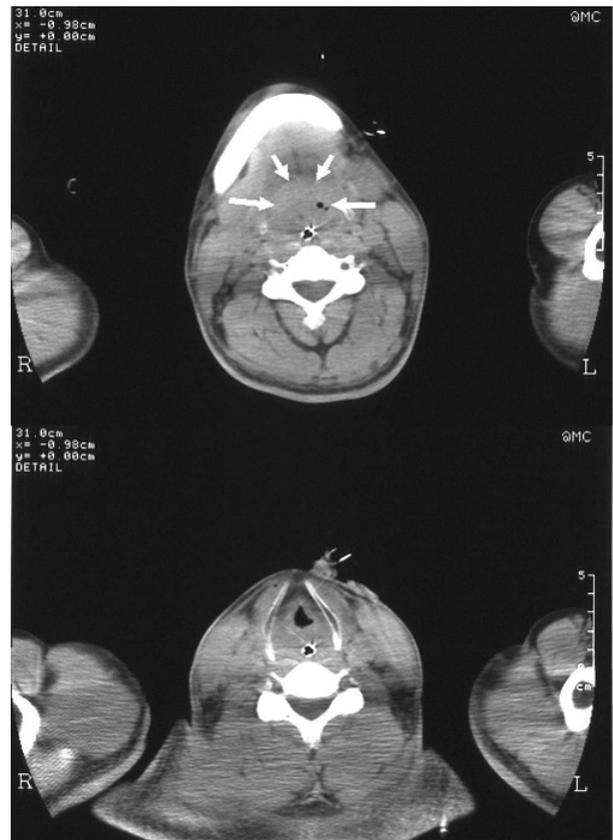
Cervical CT images :
